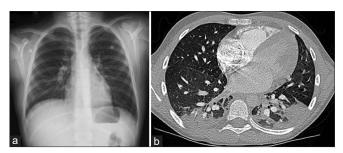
(a) Chest X-ray, anteroposterior projection. (b) Chest computed tomography of the same patient showing interstitial and alveolar infiltrates
